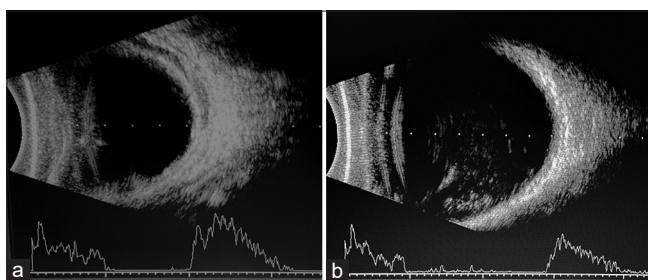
Ultrasound B scan of both eyes of father showing reduced axial length with thickened ocular coats in the right eye suggestive of pre-phthisical state (a). Left eye showing posterior vitreous detachment, low reflectivity vitreous echoes with attached retina (b)
